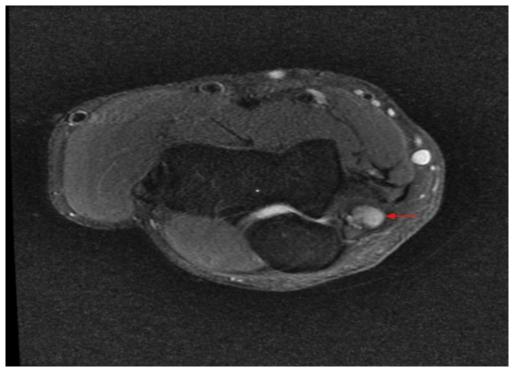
The MRI PD axial view findings shows an enlarged and thickened ulnar nerve within the cubital tunnel with an abnormal high PD signal.
